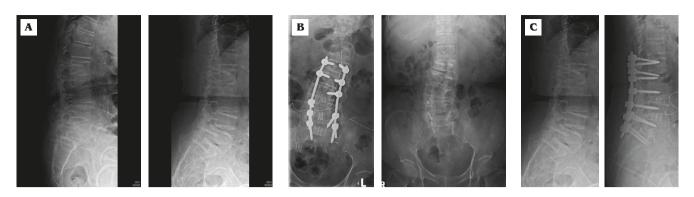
(A) Flexion-extension radiographs show L1–S1 pseudarthrosis before revision surgery. (B) Anteroposterior radiographs show the same position of the cement spacers and pedicle screws after revision surgery. (C) The same results are seen from the lateral projection.
